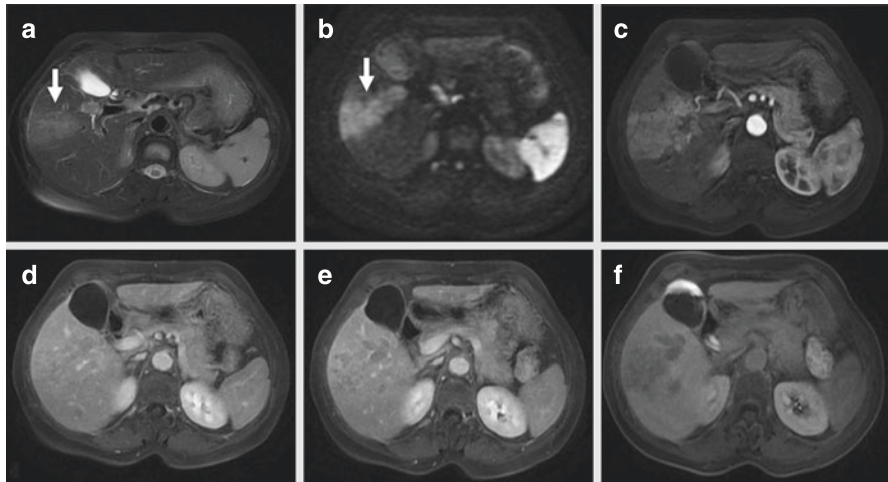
Hepatocellular carcinoma with macrovascular invasion on MRI: between hepatic segments 5 and 6 a poorly defined mass associated with neoplastic thrombus in the anterior right portal vein branch. (a) Lesion with intermediate signal on the axial T2-weighted fat saturated image. (b) Restriction on diffusion-weighted imaging (white arrows). (c) Axial T1-weighted fat saturated image during the arterial phase with lesion wash-in. (d, e) Axial T1-weighted fat saturated images during the portal venous (d) and delayed (e) phases, with lesion wash-out. (f) Contrast-enhanced MRI axial T1-weighted fat suppressed image in the hepatobiliary phase with lesion hypointensity
